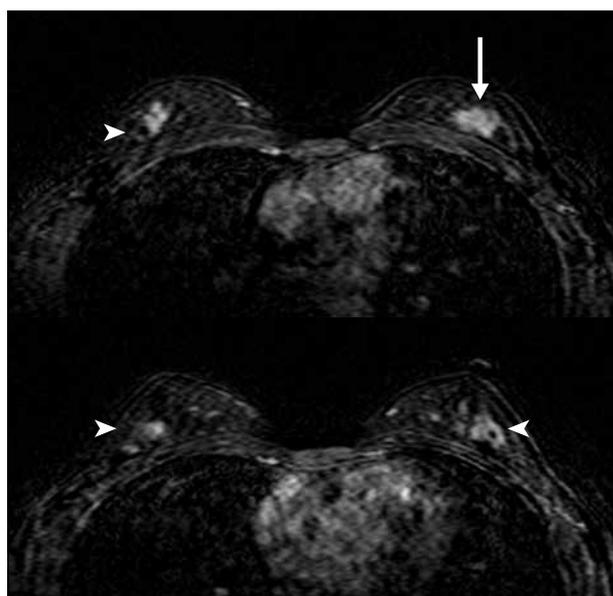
Synchronous bilateral breast cancers: contrast-enhanced subtracted axial magnetic resonance imaging shows an enhancing index lesion (arrow), with synchronous additional bilateral lesions (arrowheads) that are occult on mammogram and ultrasound. Subsequent resection confirmed bilateral ductal carcinoma in-situ.
